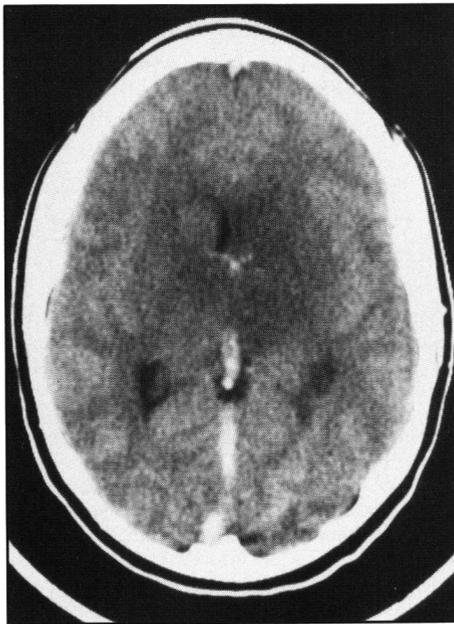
Patient 1 — Non-enhanced CT on admission. Hypodensity in the basal ganglia, thalami, left lentiform and caudate nuclei and left internal capsule with slight compression of left lateral ventricle. Hyperdensity in the thalamostriate and internal cerebral veins and straight sinus.
